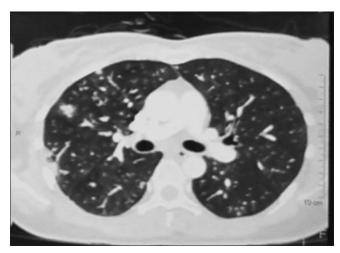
CT scan—shows multiple nodular pattern
